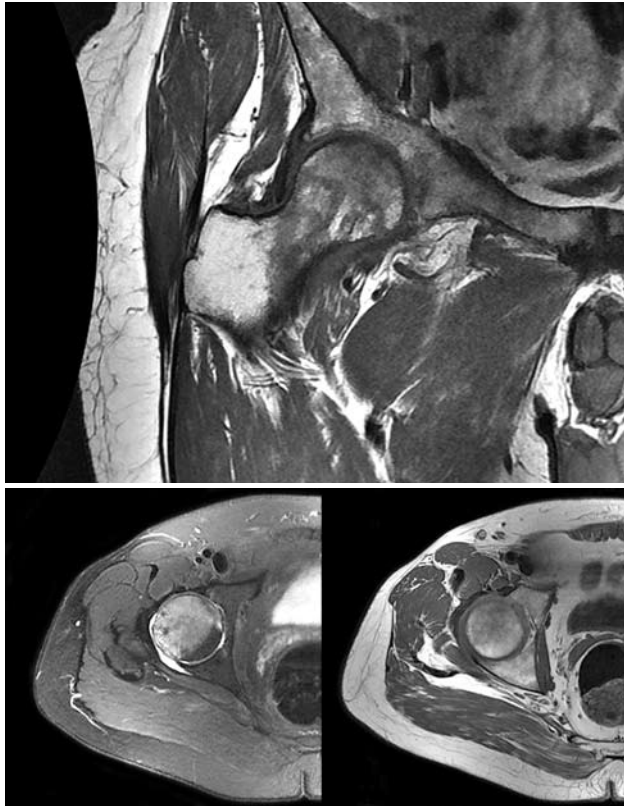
Preoperative MRI, stage IC with respect to Steinberg classification.
